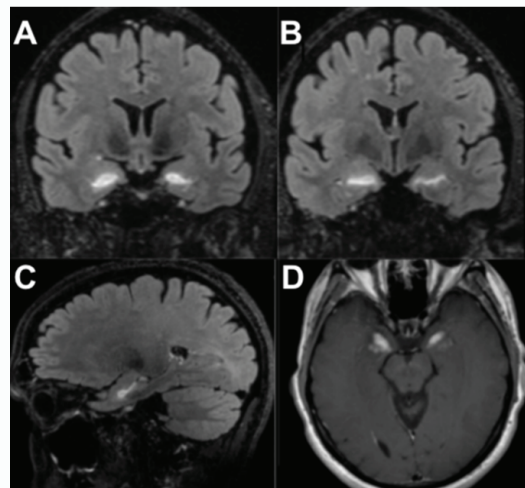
Brain MRI without contrast, showing bilateral regions of hyperintensity within the amygdala closely associated with the temporal horns of the lateral ventricles measuring 1.3 cm × 0.9 cm on the right and 1.2 cm × 0.8 cm on the left. A and B) coronal, C) Sagittal and D) Axial images.
